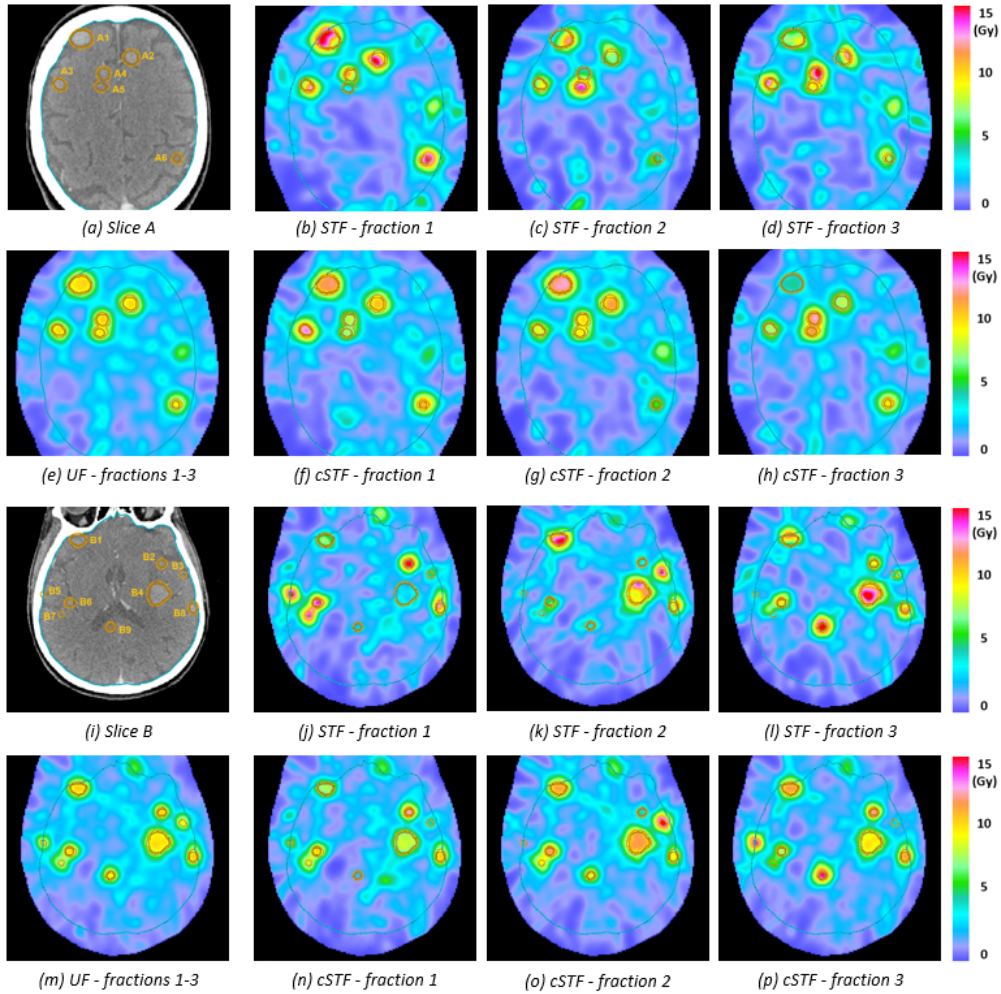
4: Dose distributions for two CT slices of patient 3 achieved with the different fractionation schemes. In slice A (a), six metastases are visible with PTV volumes of 1.7 cc (A1), 1.3 cc (A2), 0.5 cc (A3), 0.6 cc (A4), 0.5 cc (A5) and 0.7 cc (A6). In slice B (i), nine metastases are visible with PTV volumes of 1.3 cc (B1), 0.4 cc (B2), 0.4 cc (B3), 10.9 cc (B4), 0.3 cc (B5), 0.4 cc (B6), 1.4 cc (B7), 0.6 cc (B8) and 0.5 cc (B9). For each lesion, both contours for the GTV (brown) and PTV (orange) are shown. Also shown is the contour of the brain (light blue).
